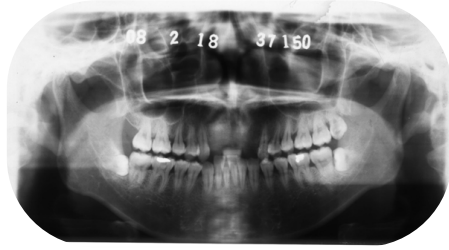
Pretreatment panoramic radiograph showing impacted mandibular third molars, sound tooth structure, and generalized alveolar marginal bone loss.
